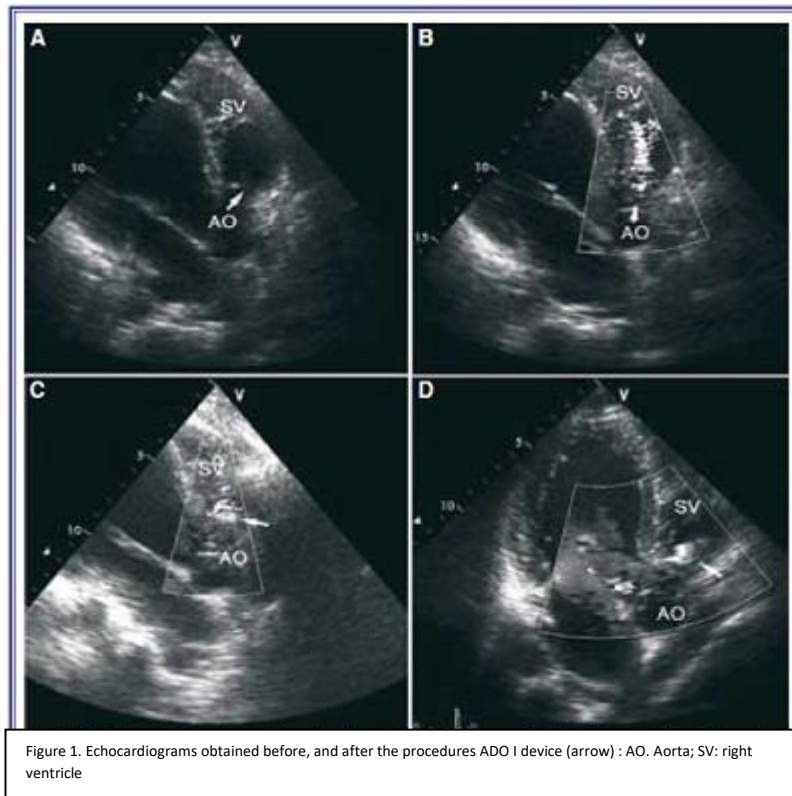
Echocardiograms obtained before, and after the procedures ADO I device (arrow) : AO. Aorta; SV: right ventricle
